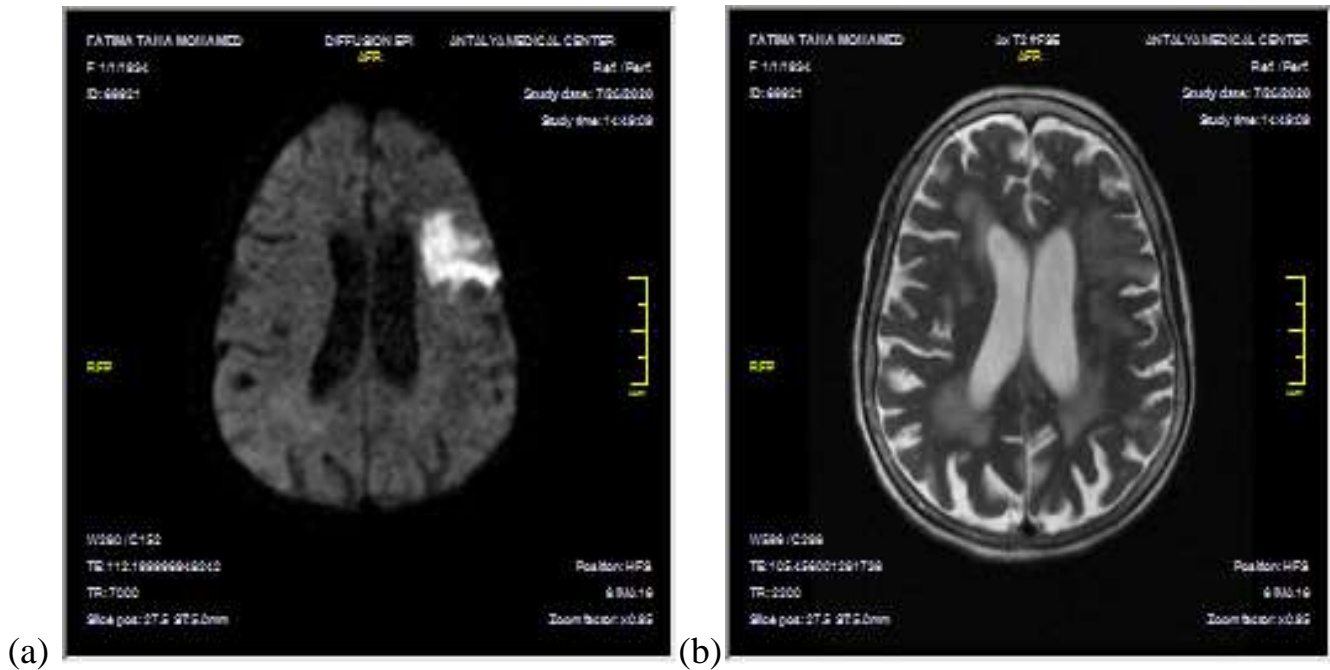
Case study 10: Left temporal acute infarction detected in DWI, and T2WI of a 86-year-old female patient. MR images were obtained 10 h after the onset of symptoms. (a) A bright signal lesion at the lateral part of the left temporal region on the DW image. (b) a low signal at the same site. DWI: diffusion-weighted MRI; T2WI: T2-weighted imaging.
